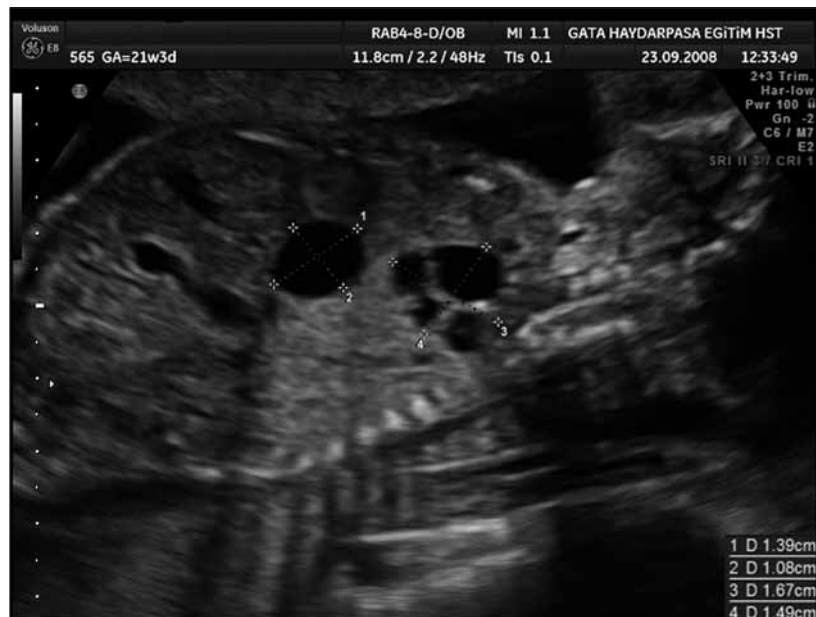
Shape 1. Sagittal ultrasonographic section of thorax in the fetus with type I congenital cystic adenomatoid malformation, showing cystic lesions in the left lung region.
